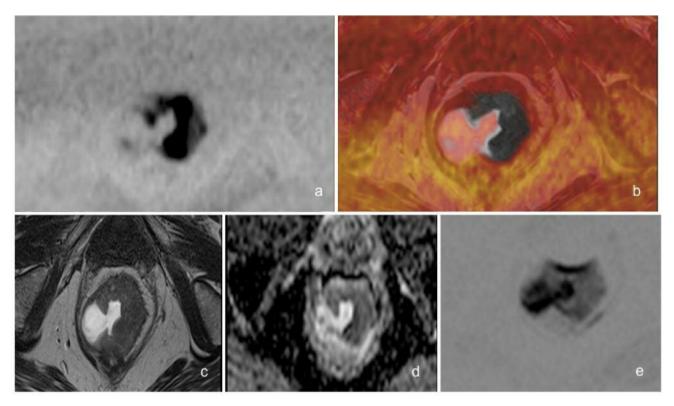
Imaging of primary rectal cancer (T3) in a 73-year-old man. a: The rectal cancer is clearly visible on b2000 diffusion-weighted imaging (DWI); b: fusion of b2000 DWI image with a 2D axial T2-weighted sequence (T2WI) adds morphological information of surroundings. c: 2D Axial T2WI for the same location as shown in (a.) d: Apparent diffusion coefficient map also showed the tumor clearly. e: Slight image torsion and artifacts due to feces on b800 DWI.
